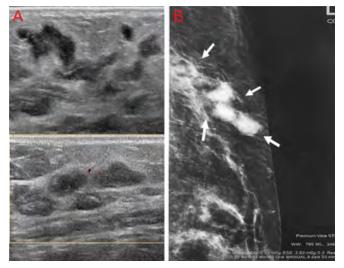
Imaging finding of sparganosis of the breast. (A) Ultrasound finding: sheet or strip area of low echo is seen at the subcutaneous to glandular layer with internal hyperechogenicity; (B) Mammography finding: a tubular elongated curved structure (arrows) sapparent in the subcutaneous fat layer.
